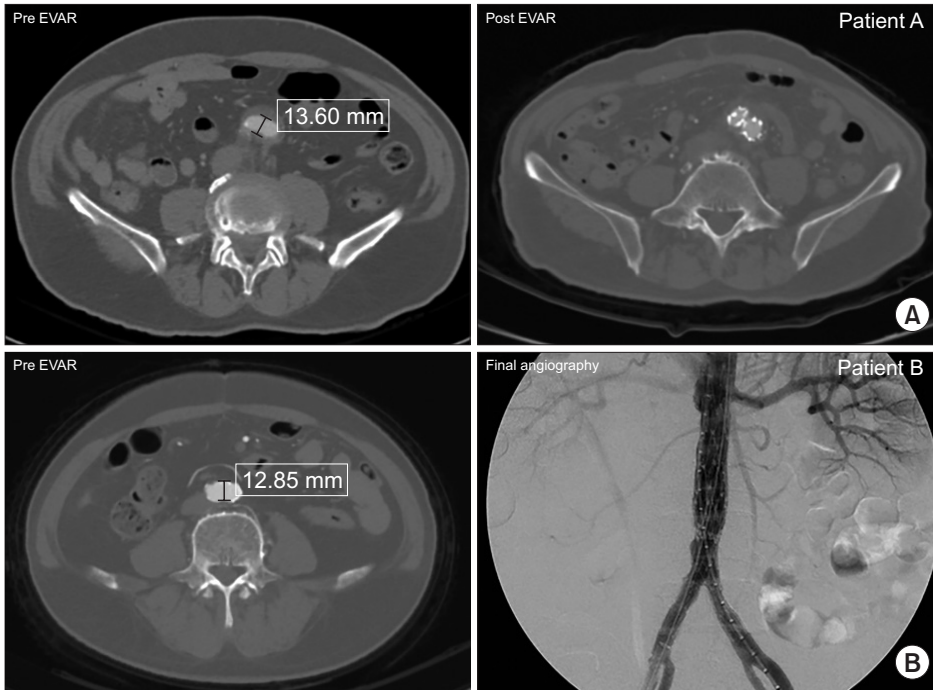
Distal narrow aorta. Follow-up computed tomography after the AFX2 was deployed to 12 mm and 13 mm in the distal narrow aorta (A). The lumens of both limbs are patent. Both limbs are also shown well on the procedural angiography (B). EVAR, endovascular aneurysm repair.
